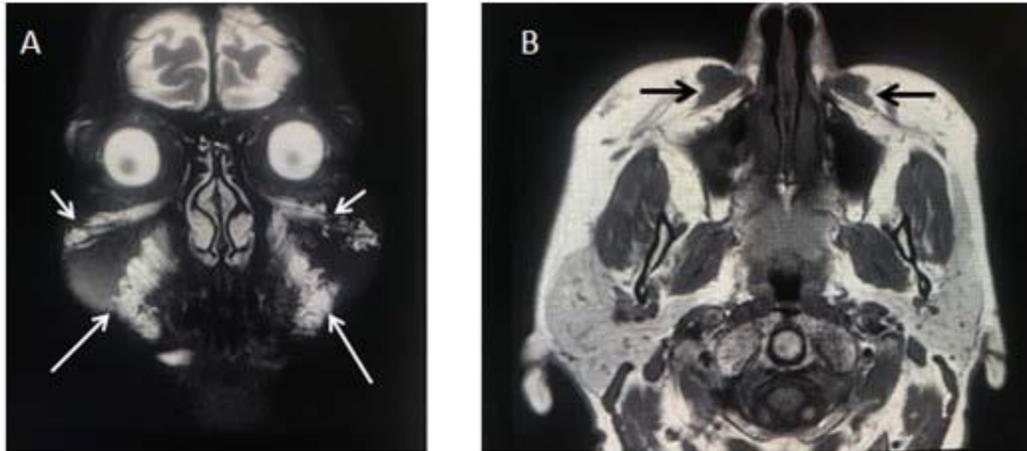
A - Coronal STIR MRI image shows the typical hyperintensity of the bilateral hyaluronic acid injections in the inferior orbital compartments (short arrows) and nasolabial fat compartments (long arrows) and B - axial T1 MRI shows the hypointense signal in the nasolabial fat compartments (arrows)
